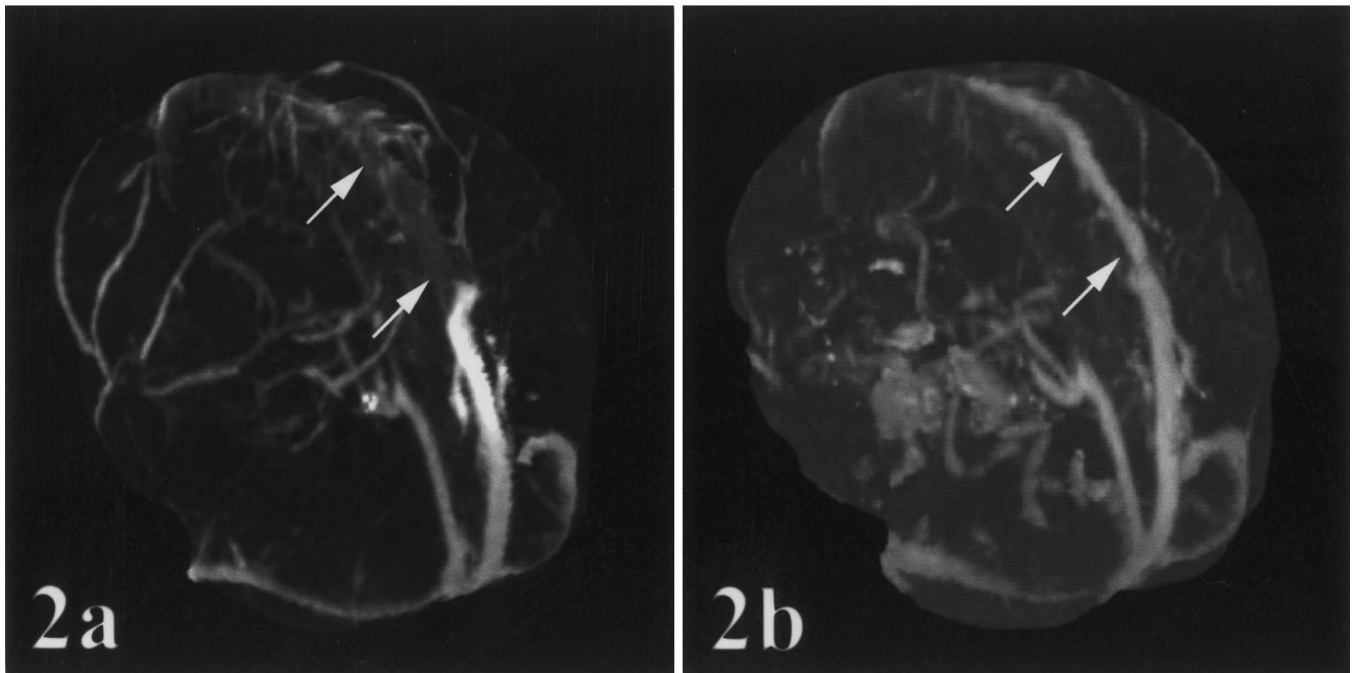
Three-dimensional reconstruction of the CT venogram, posterior oblique views. (a) Initial study, showing non-opacification of the anterior and mid-portions of the superior sagittal sinus (arrows). (b) Follow-up image after treatment with low molecular weight heparin, showing opacification of the entire superior sagittal sinus (arrows).
